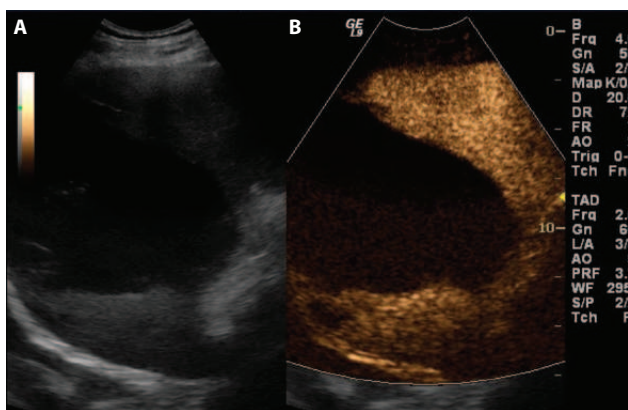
Contrast enhanced sonography of the spleen in a 71-year-old male. The basic sonography (A) confirmed splenomegaly with the presence of a lesion 13.5×10.6 cm, without the characteristics of a plain cyst, as it was more hypoechoic, with amorphous material within the lesion and with well-defined borders. The Doppler appearance showed no vascularization. After intravenous administration of contrast agent (B), while the splenic parenchyma was enhanced in a homogenous manner, this lesion remained without any enhancement at any phase of the contrast-enhanced sonography.
